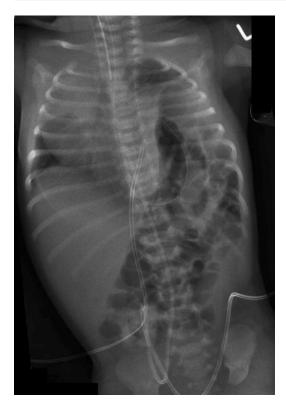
Congenital diaphragmatic hernia. Plain chest and abdominal radiograph demonstrates large left diaphragmatic hernia. Note the course of the NG tube confirming the intrathoracic position of the stomach
